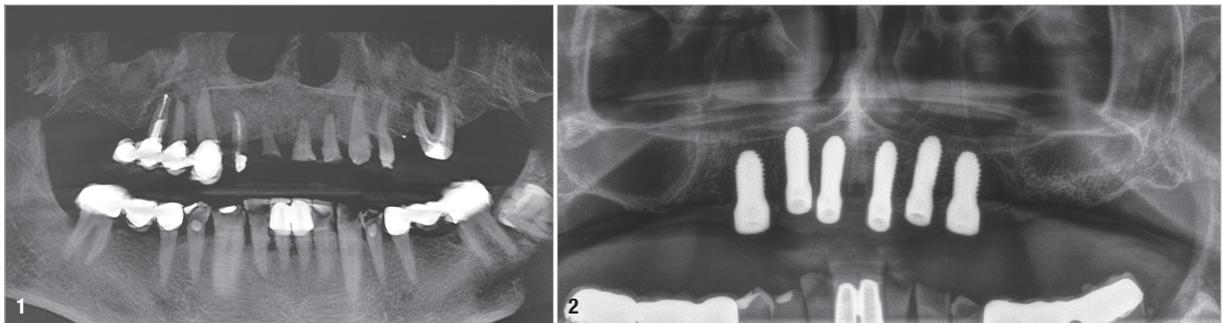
Pre-op radiograph revealing severely pronounced atrophy in the maxilla. Fig. 2: Six zirconia implants were placed in the patient's maxilla.
